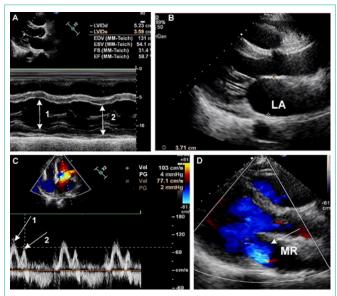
(A) Echocardiography showing: ejection fraction; (EF) 59%, improvement of cardiac contractility: diastolic Inner Diameter of Left Ventricular (LVIDd): 5.23cm (arrow 1), systolic Inner Diameter of Left Ventricle (LVIDs): 3.59cm (arrow 2). (B) Evaluation of the Left Atrial (LA) size, the anteroposterior distance of LA is 3.71cm. (C) Evaluation of E peak (arrow 1) and A peak (arrow 2) of mitral valve forward flow. (D) Echocardiography showing regurgitation of mitral valve (MR) (white arrow). Ao: Aorta; EDV: End-Diastolic Volume; ESV: End-Systolic Volume; FS: Fractional Shortening.
